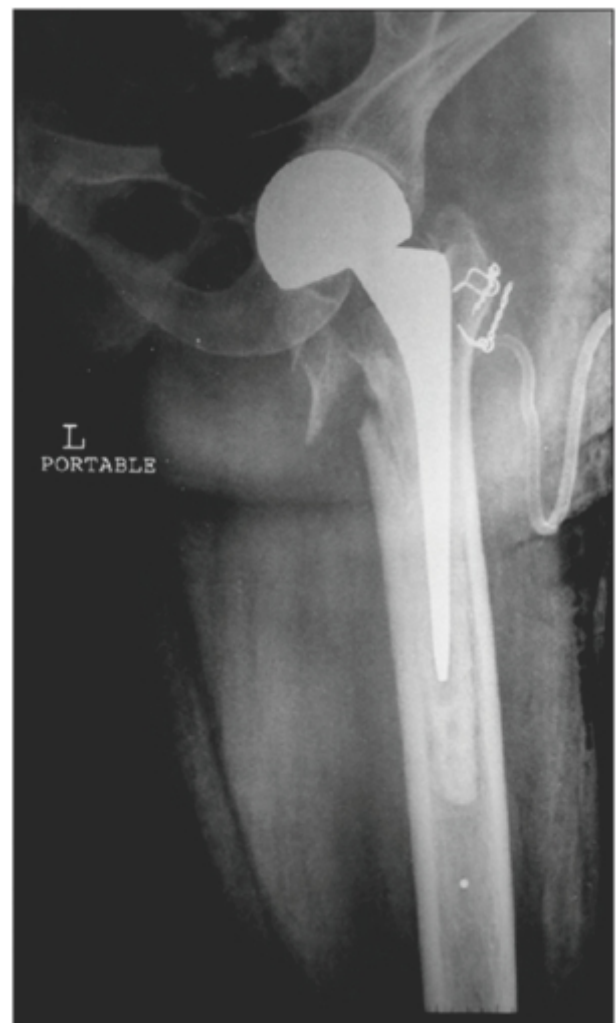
Immediate postoperative anteroposterior radiograph showing the graft and the implant
